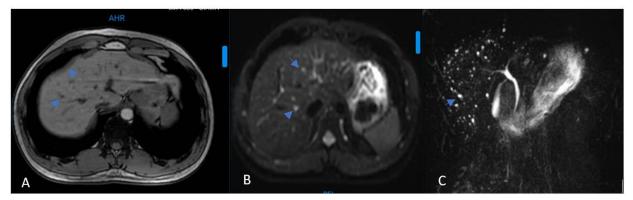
A: T1-weighted image obtained after intravenous administration of a non-liver-specific gadolinium chelate during the interstitial phase shows focal liver lesions with no enhancement (arrows);
